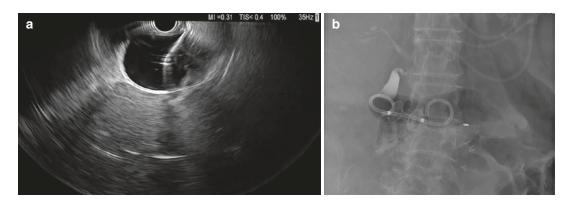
Transmural EUS-guided gallbladder drainage. (a) From the antrum of the stomach or the proximal duodenum the gallbladder can be seen endosonographically. A cautery-enhanced catheter housing a lumen-apposing metal stent (LAMS) can then be passed into the gallbladder body. (b) The LAMS is then deployed thereby creating an anastomosis between the gallbladder and gastrointestinal lumen. A short double-pigtail stent is placed to minimize mucosal irritation from the stent and prevent stent migration/separation resolution of cholecystitis, need for re-intervention, mean pain scores, adverse events, and hospital length of stay, favoring EUS-GBD [32]. More recently, a randomized trial (DRAC 1) of 80 patients comparing PC and EUS-GBD demonstrated that EUS-GBD significantly reduced 1-year adverse events, 30-day adverse events, and re-interventions with equivalent technical and clinical success rates [33].
